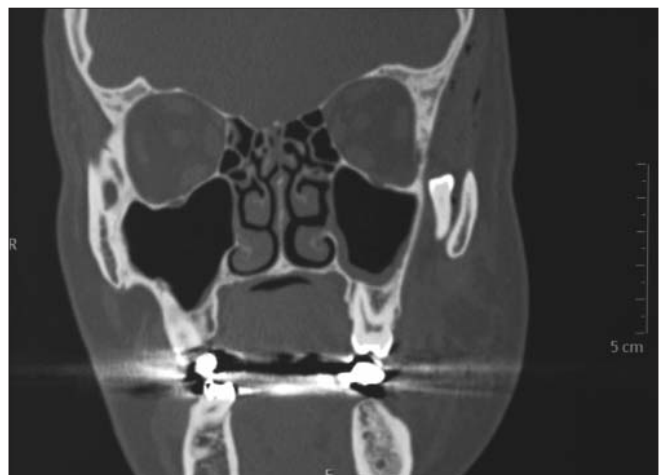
Coronal preoperative CT scan indicates the position of the impacted tooth, close to the zygomatic arch and fully developed
